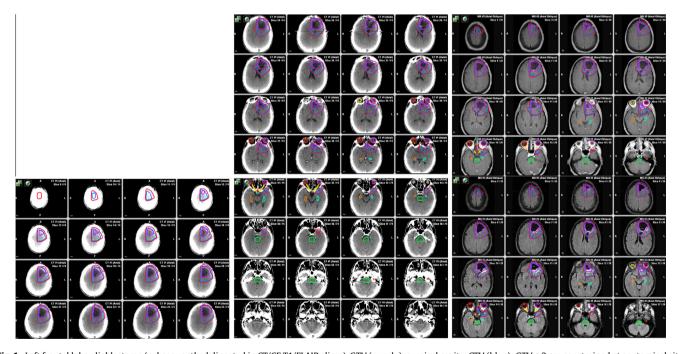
Left frontal lobe glioblastoma (subsequently delineated in CT/CE T1/FLAIR slices), GTV (purple): surgical cavity, CTV (blue): GTV + 2 cm constrained at anatomical sites; falx (5 mm) (CT slices 10–40, T1 slices 2–13, FLAIR slices 2–13), cavernous sinus, optic chiasm (0 mm) (CT slices 40–41, T1 slices 13–14, FLAIR slices 13–14), bone (0 mm) (all slices and series). PTV (red): CTV + 3 mm. Organs at risk: Brainstem (light green), optic chiasm (sky blue), left optic nerve (lime green), right optic nerve (yellow), left eye (pink), right eye (red), left lens (slate blue), right lens (dark orange), right hippocampus (orange), left cochlea (brown).
